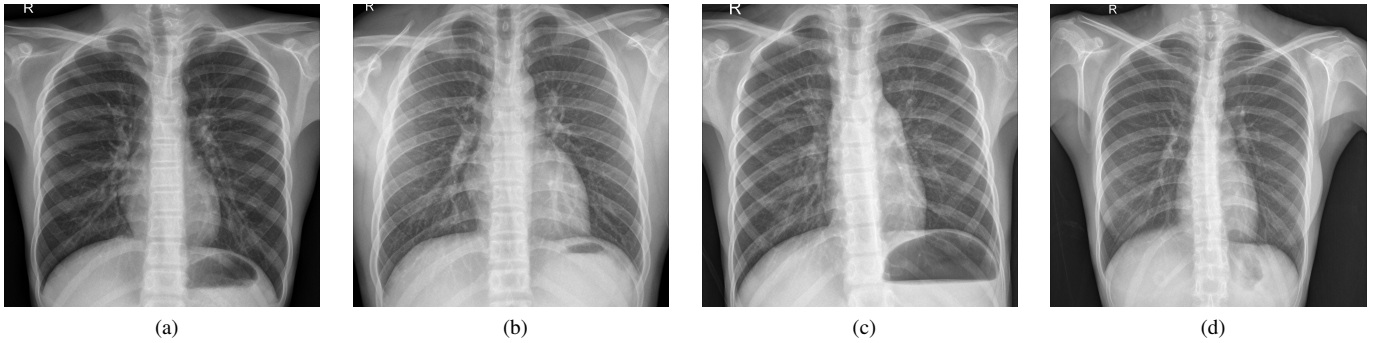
Normal Chest X-ray Images. Lung, Heart and diaphragm are clearly visible.
